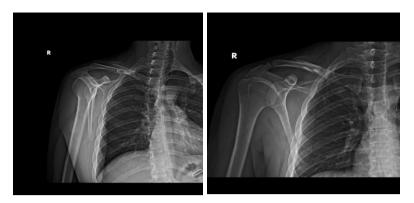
Preoperative X-ray image
